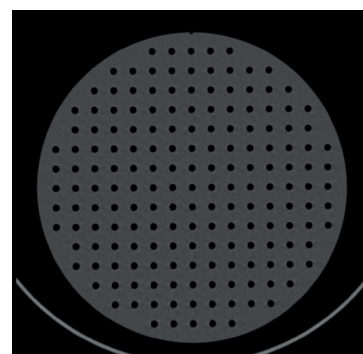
CT Image showing image distortion analysis
